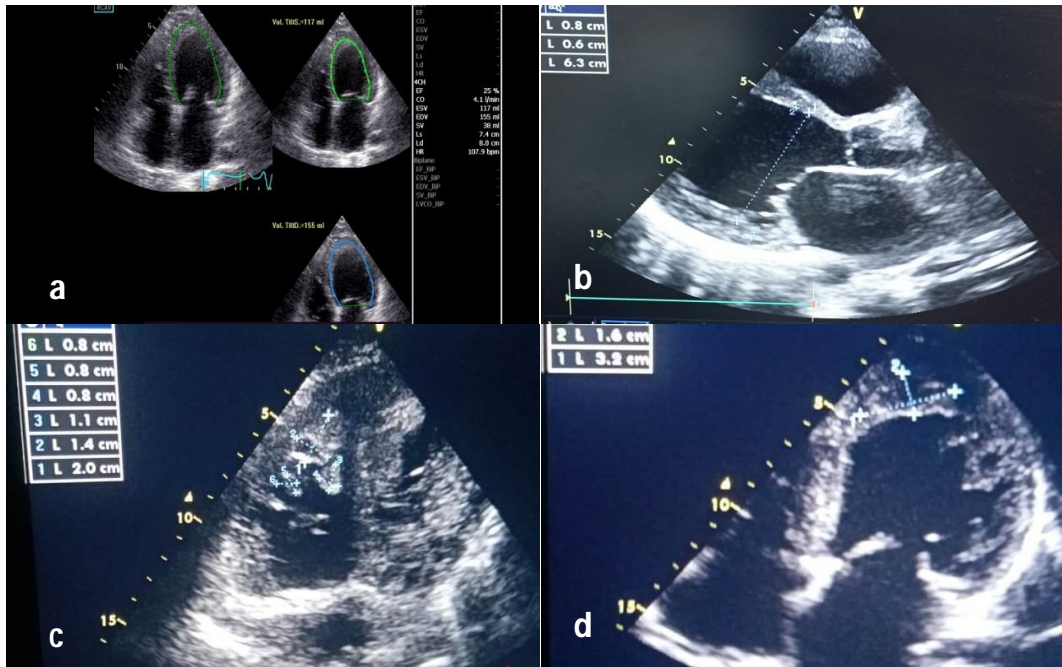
Transthoracic echography 2D initial evaluation : a) : Severe left ventricle dysfunction by automatical systolic ejection fraction ;b) :large dilatation of left ventricle ; c):Magma of thrombus in right ventricule apex; d): adherent thrombus in left ventricule apex
